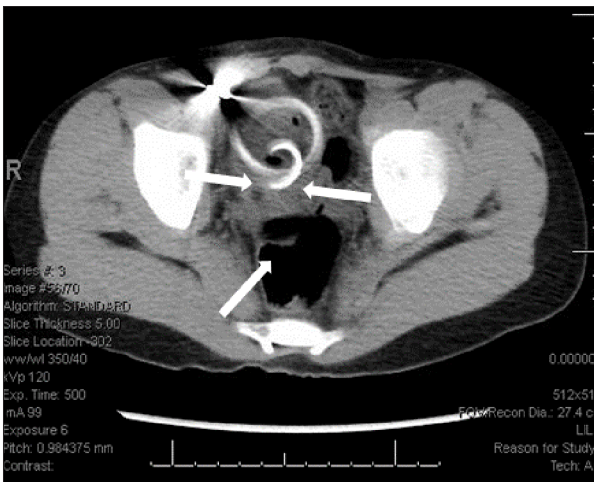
Abdominal CT scan transverse view showing the entry of PD catheter in sigmoid colon (arrows).
